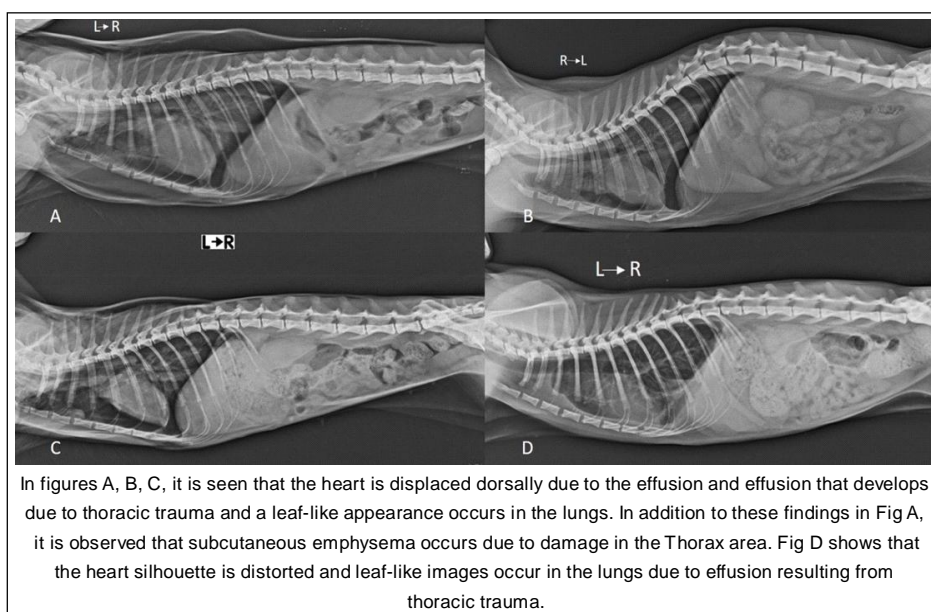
Some radiographic images of cases with thoracic trauma.
